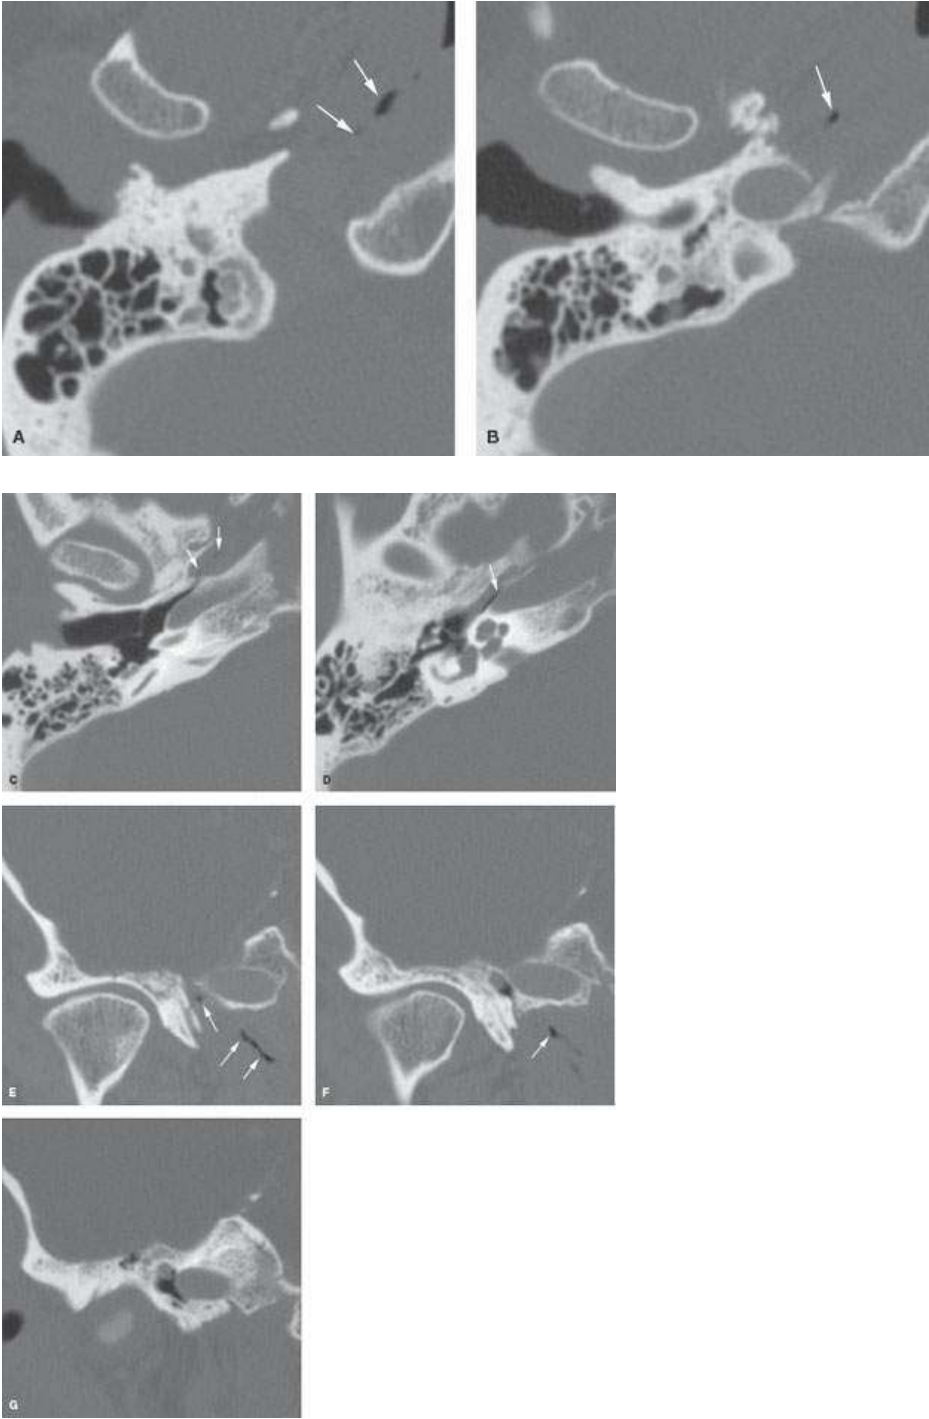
Axial (A–D) and Coronal (E–G) CT image of cartilaginous portion of the eustachian tube. The eustachian tube connects the middle ear to the nasopharynx. It contains a bony part, which can be seen anteriorly to the horizontal segment of the carotid artery, and a cartilaginous portion, which can occasionally be seen filled with air (*arrows*). It is very important to understand the anatomic relationships of the eustachian tube when evaluating a patient for unilateral middle ear disease.
